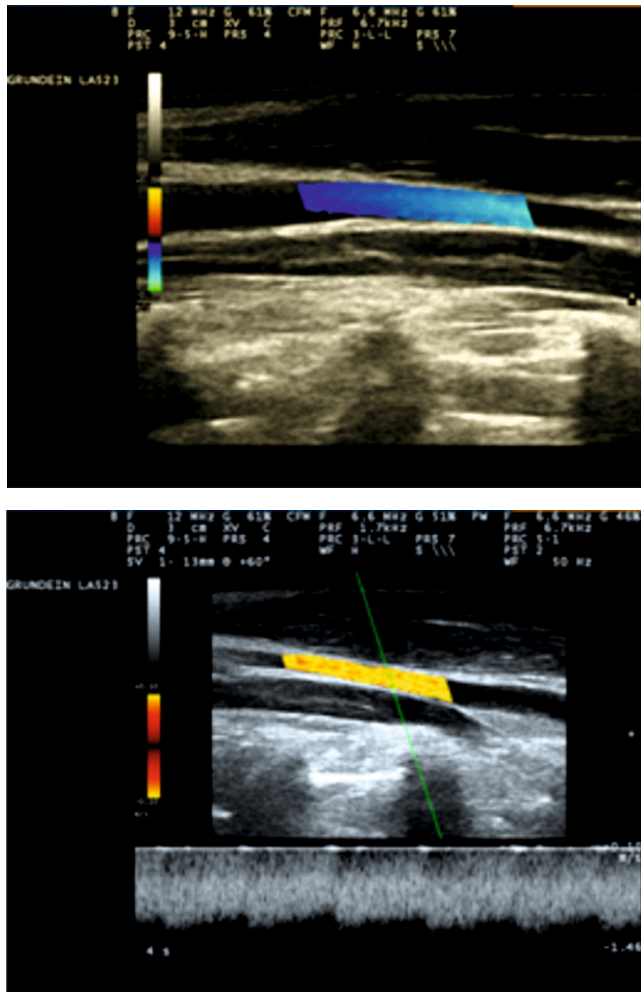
Doppler color flow (above) and spectral Doppler interrogation (below) of left jugular vein - characteristic continuous spectral blood flow
